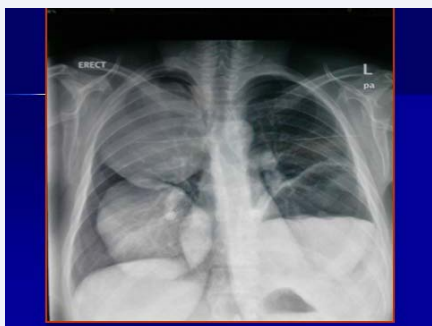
Chest X-ray showing two intact hydatid in the left lung and one ruptured Cyst in the right lung.
